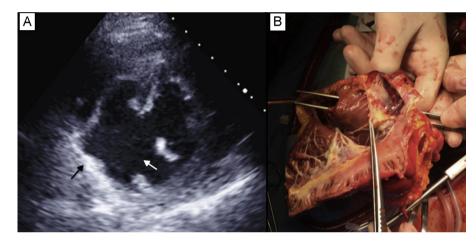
A: Echocardiogram showing the ventricular septal defect (white arrow) and pseudoaneurysm (black arrow). B: Explanted heart; the right ventricle is open and tweezers introduced through the aortic valve pass through a large ventricular septal defect in the posterior part of the septum.
